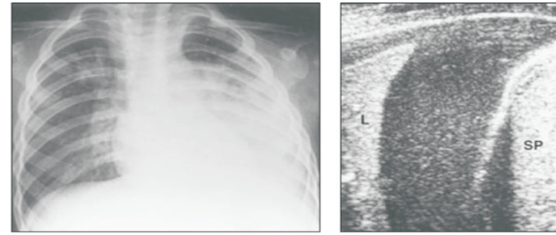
Ultrasound image of the complicated parapneumonic effusion
